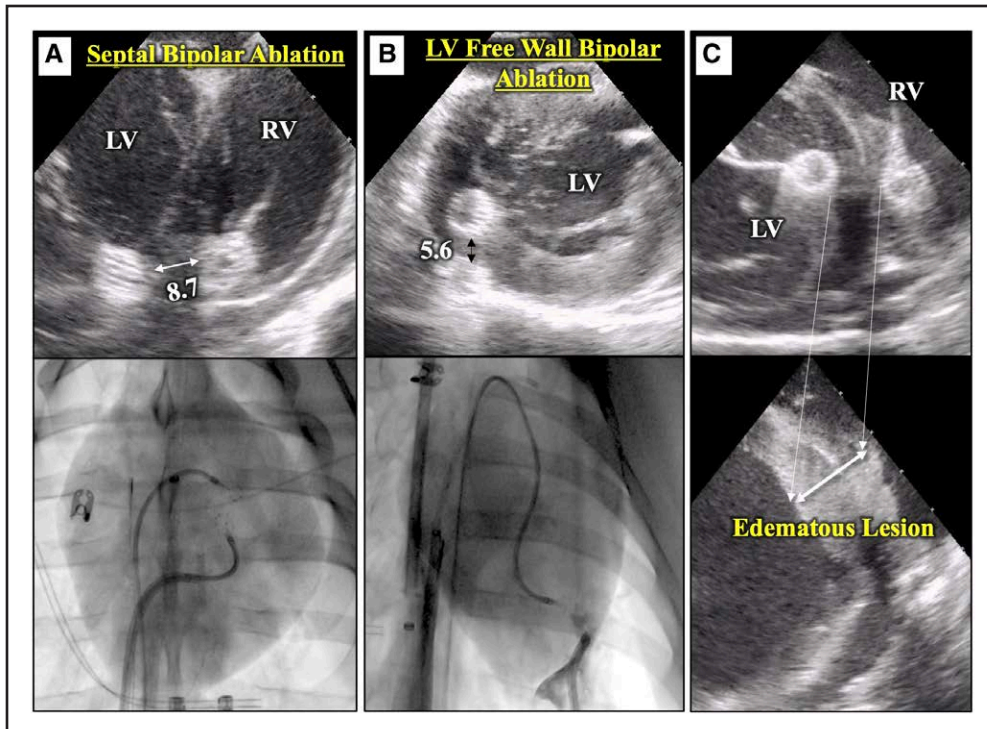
Bipolar ablation–intracardiac echocardiography (ICE) and fluoroscopic views.
